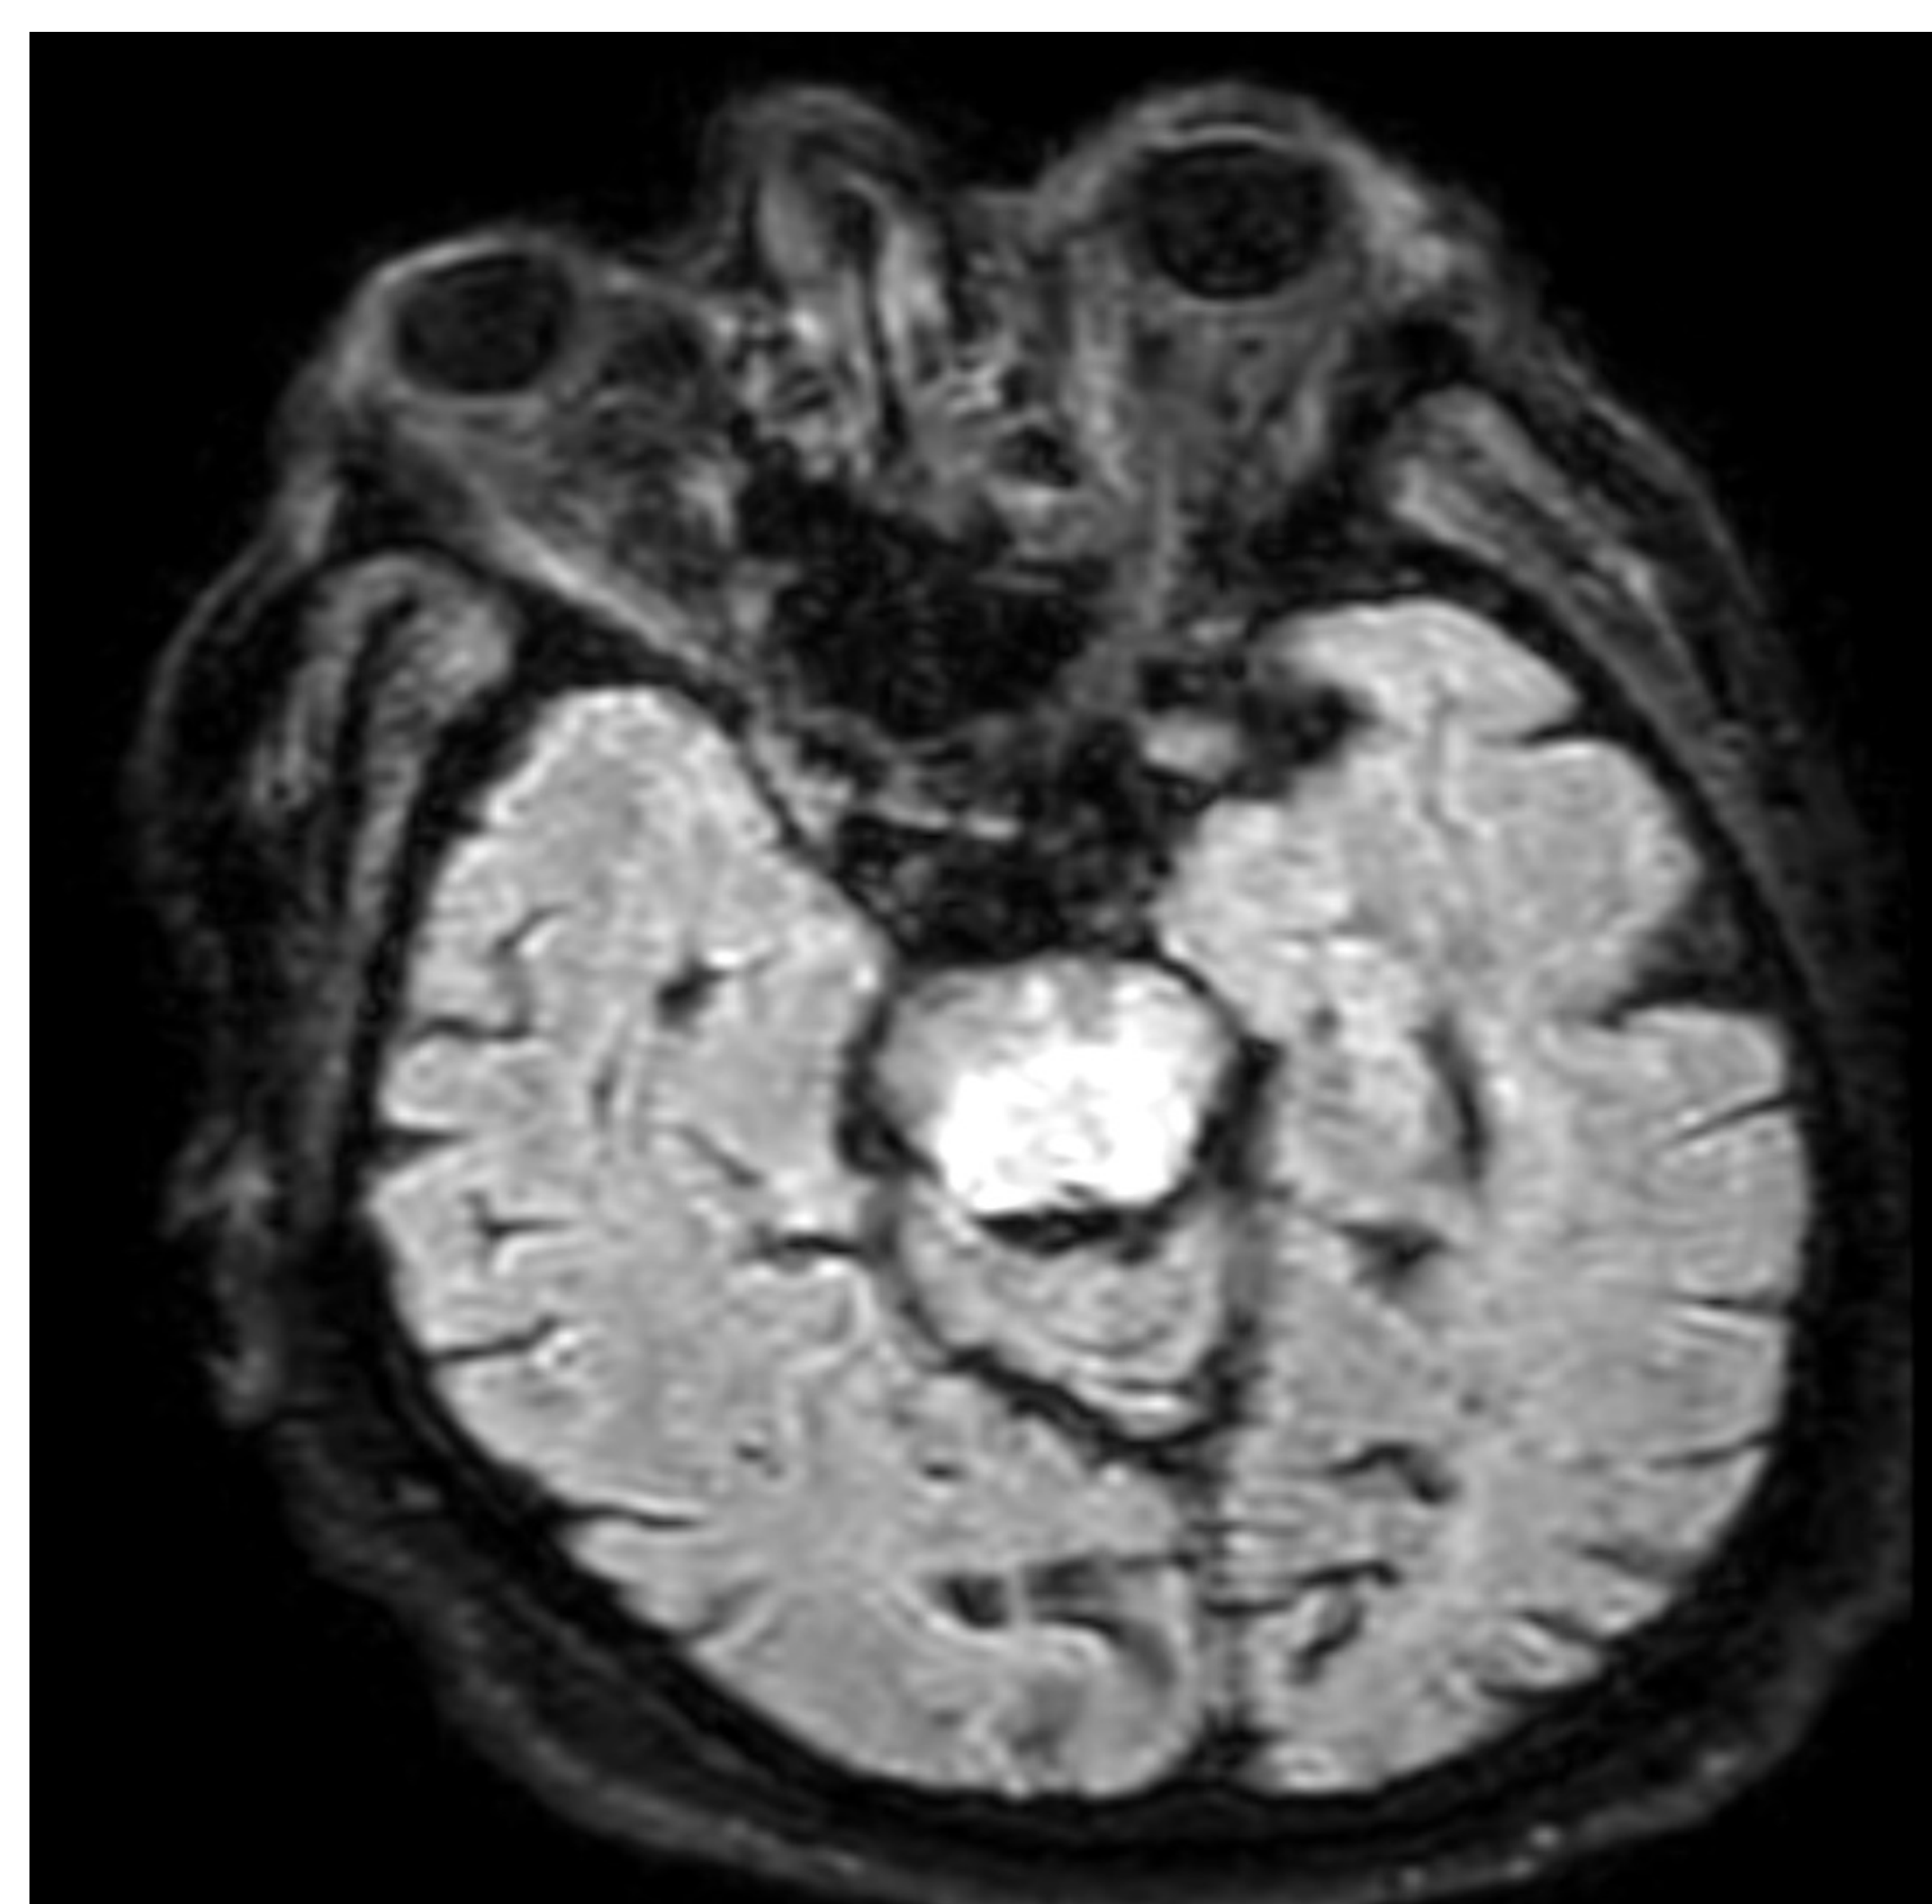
Axial T2 FLAIR images demonstrate extension of the T2 hyperintense signal into the pons, sparing the periphery and the corticospinal tracts, giving the characteristic "trident" appearance (outlined in red dotted line) seen in osmotic demyelination syndrome.
